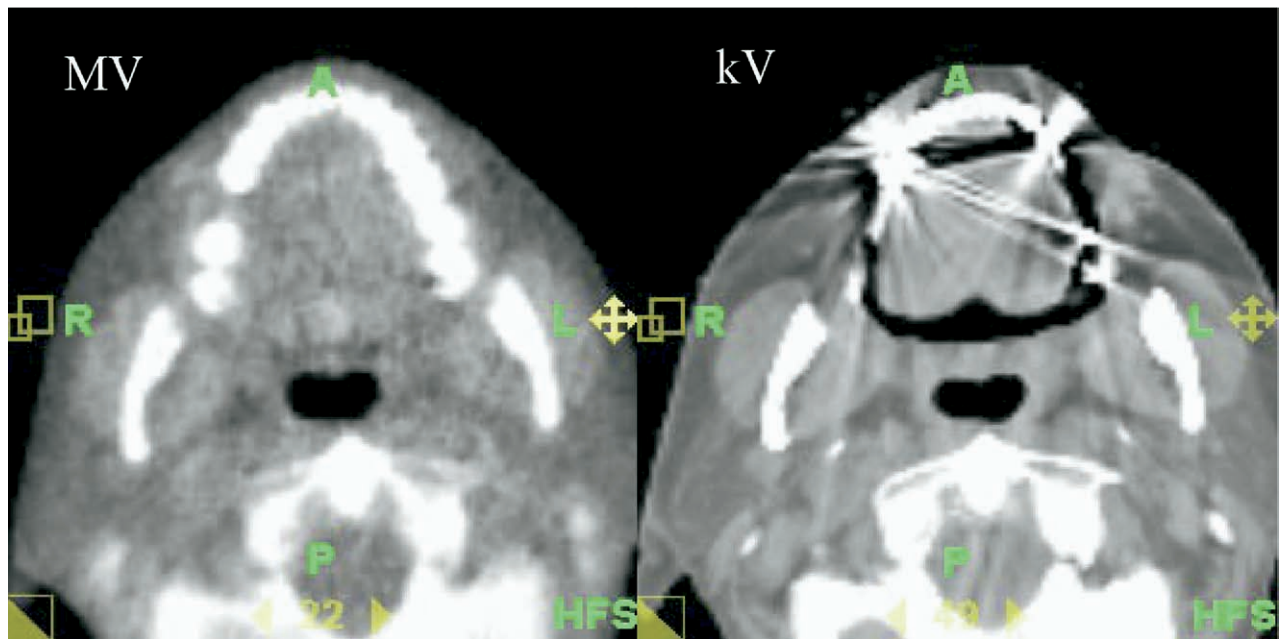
Comparison of megavoltage CT vs. kilovoltage CT. Image artifacts due to high Z tooth fillings are eliminated in the MVCT image at the cost of lower soft-tissue contrast.
